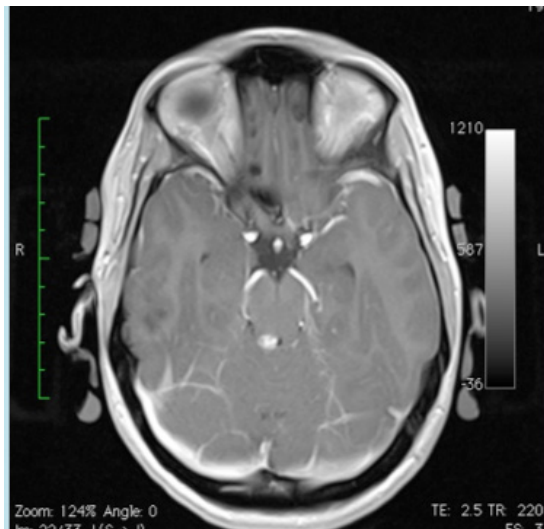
Magnetic resonance imaging of a horizontal section at the level of the mesencephalon. Note the presence of a small haemorrhage in the right colliculus superioris.
